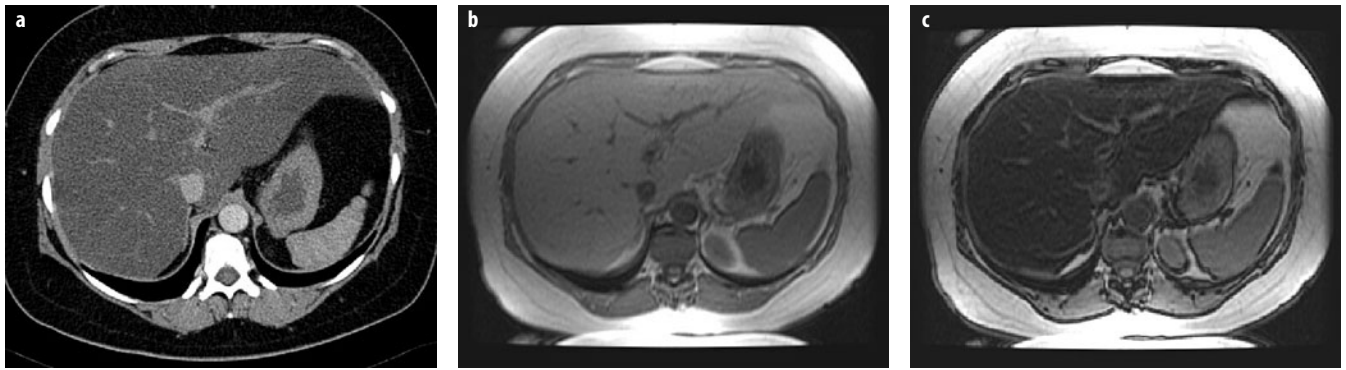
a-c. Diffuse fatty liver. A 41-year-old woman presenting with epigastric pain. a Axial contrast-enhanced computed tomography image demonstrates diffuse low attenuation of the liver without displacement of the hepatic vessels. b In-phase and c out-of-phase T1-weighted images show significant signal drop in the liver on the out-of-phase images. Reproduced from Hodler J, von Schulthess GK, Zollikofer ChL (Eds) (2010) *Diseases of the Abdomen and Pelvis 2010-2013*. Springer-Verlag Italia, Milan, pp. 56-60
